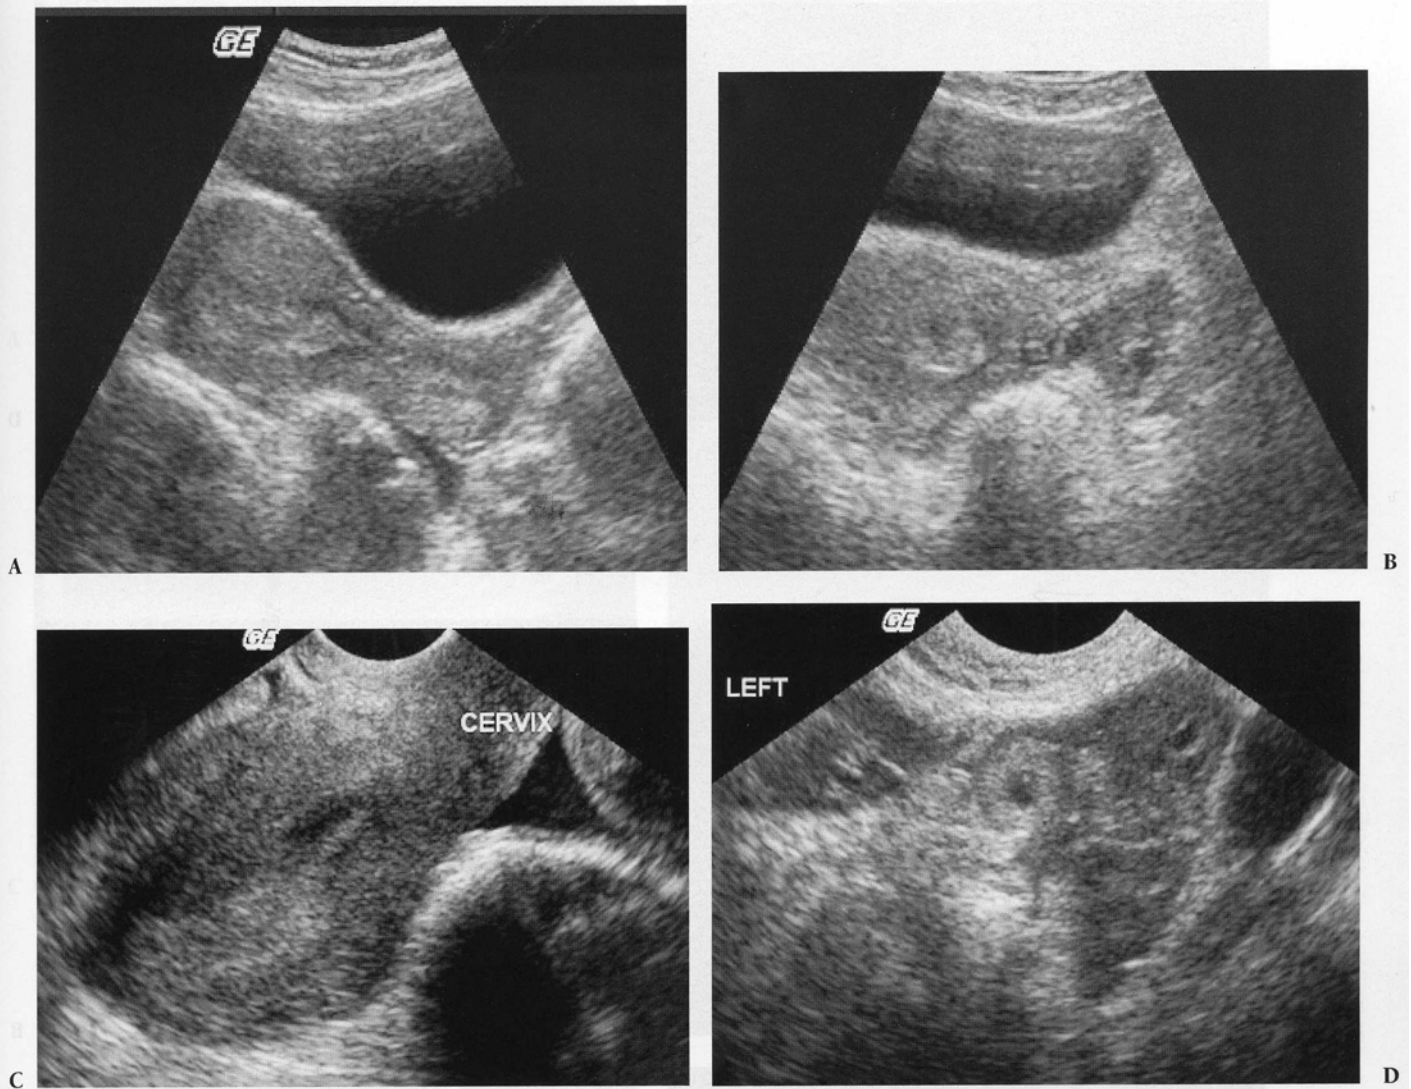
IUP in a Bicornate Uterus. Image courtesy of Kendall JL, Deutchman M. *Ultrasound in Emergency Medicine and Trauma*. Nashville:Healthstream 2001.
